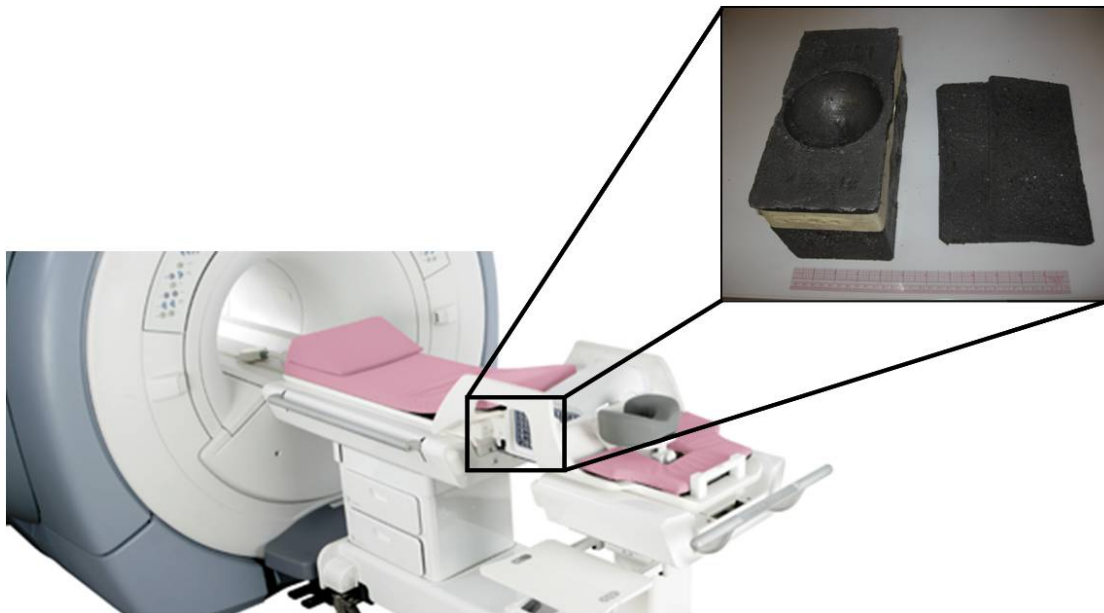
PG Foam compatible with Sentinelle Breast MRI Table (www.sentinellemedical.com).
